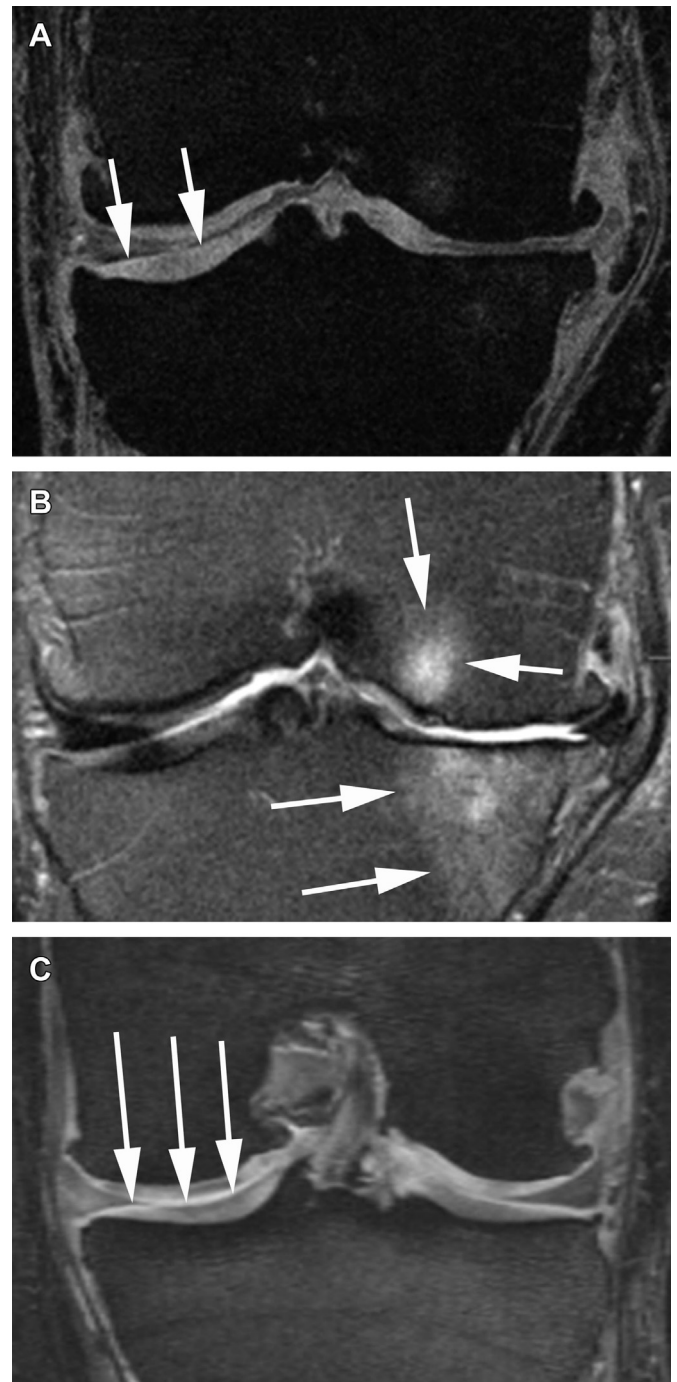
Comparison of different MRI sequences for assessment of cartilage. A. Coronal 3D FLASH image depicts the articular cartilage with high signal. Medial tibial cartilage coverage is preserved in this patient (arrows). B. Corresponding proton density-weighted fat suppressed image shows mixed signal intensity in the preserved cartilage medially. Note, in addition subchondral BMLs are superiorly depicted when compared to the FLASH sequence (arrows). C. Example of the DESS sequence, which depicts cartilage also with high signal intensity and is commonly used for cartilage segmentation (arrows).
